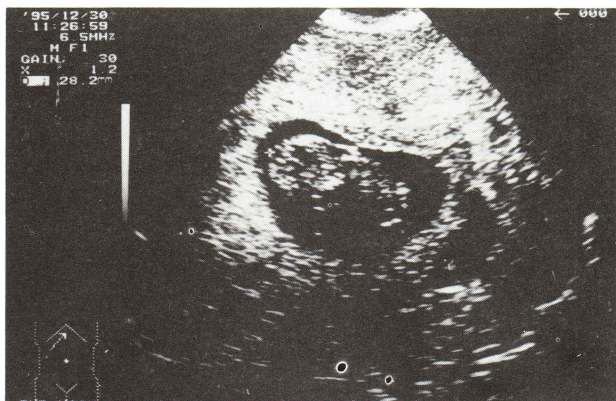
Ultrasound picture of the pregnancy at 8th week, showing the gestational sac and the fetus CRL of 28.2 mm.
